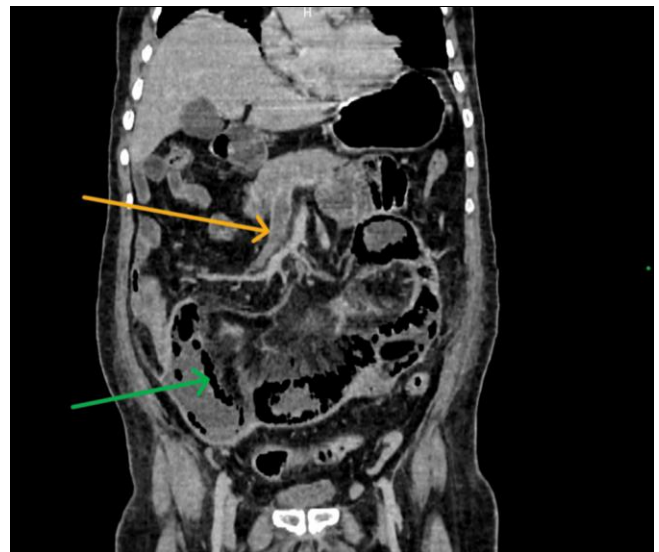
Axial Contrast Enhanced Computed Tomography of abdomen in arterial phase shows intramural gas (Green arrow) within the bowel wall, appearing as linear and cystic lucencies consistent with pneumatosis intestinalis
